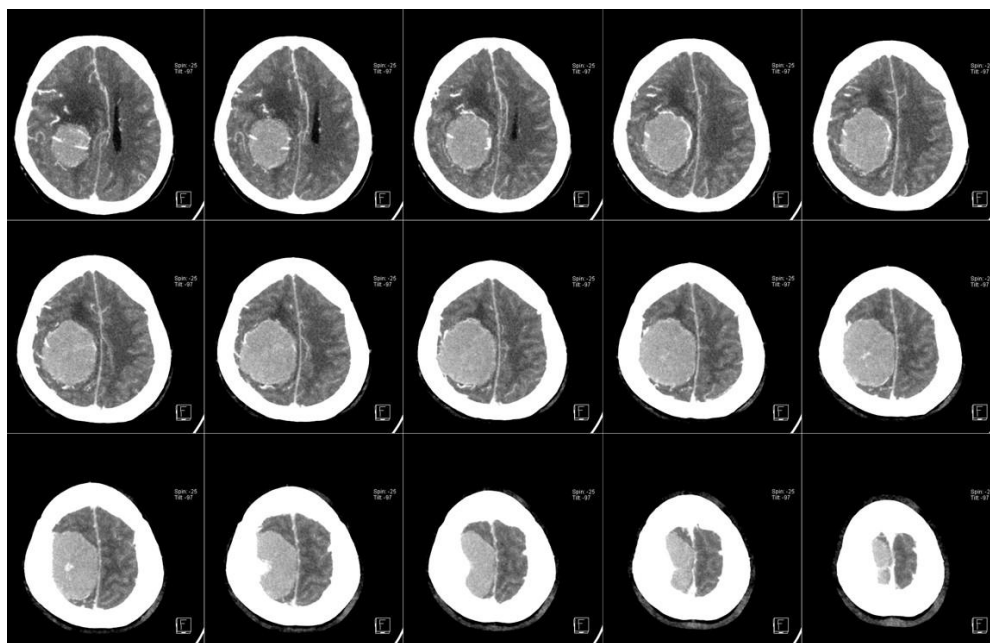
Head CT-Scan with contrast pre-craniotomy.
